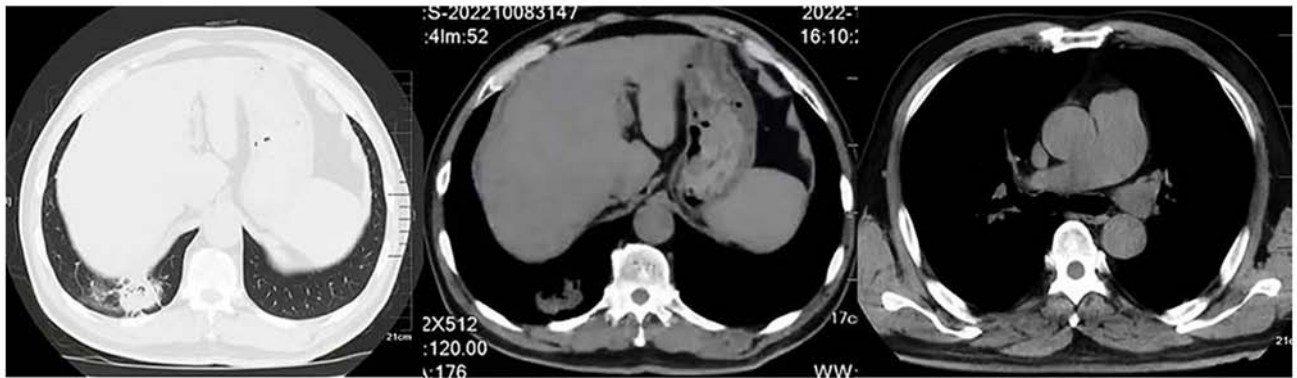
Computed tomography scan of the patient after two cycles of neoadjuvant therapy with immune combination chemotherapy showed a significant reduction in the right lung mass and mediastinal lymph nodes compared with the pre-treatment period.
